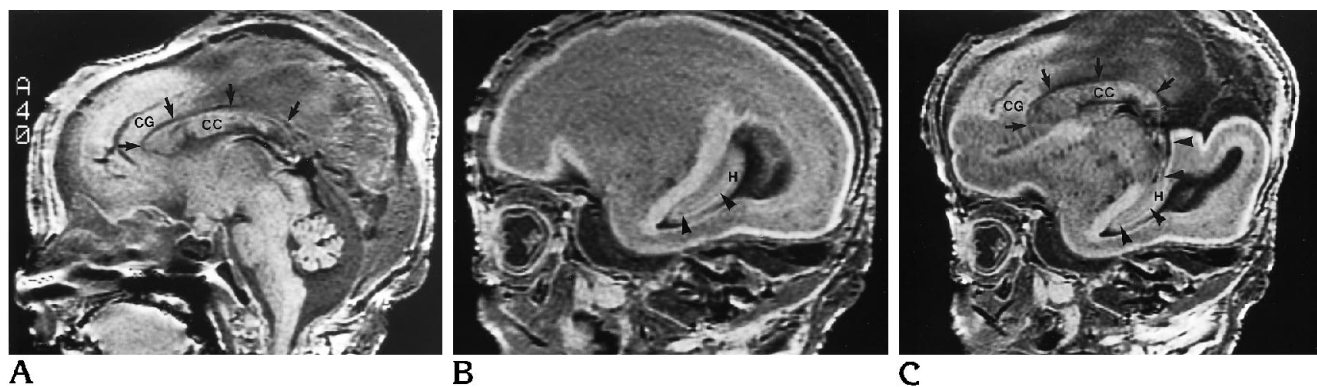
T1-weighted MR images of an 18-week-old fetus. *A*, midsagittal, *B*, parasagittal, and *C*, reformatted oblique sagittal views. The sulcus of the corpus callosum (*arrows*), between the corpus callosum (*CC*) and cingulate gyrus (*CG*), is the remnant of the anterosuperior aspect of the hippocampal sulcus (*arrowheads*). The reformatted oblique sagittal image (*C*), acquired as described in Figure 4, confirms continuity of the sulcus of the corpus callosum (*arrows*) and the hippocampal sulcus (*arrowheads*). The hippocampal formation (*H*) is visible in the temporal lobe region.
